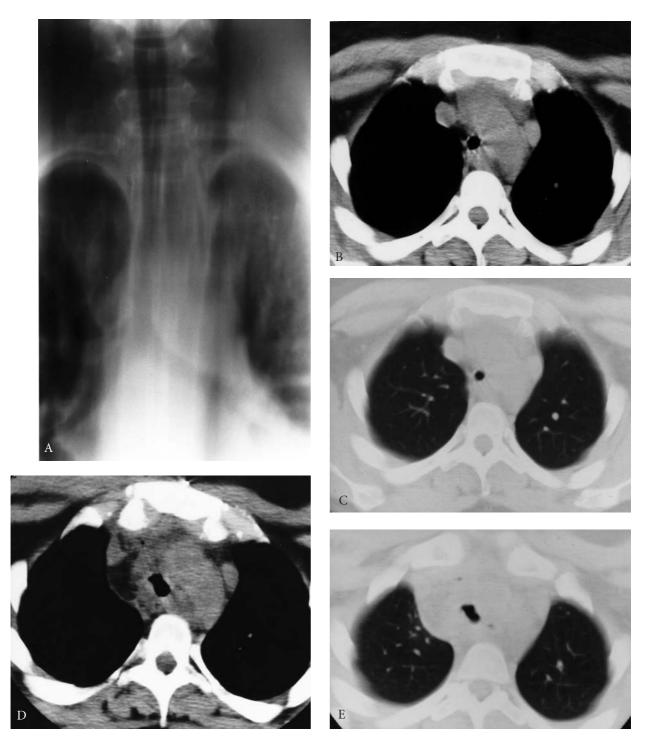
Congenital tracheal stenosis. A, Coronal tomogram demonstrates diffuse stenosis of the intrathoracic trachea. B, Computed tomography image through the midtrachea reveals a complete cartilaginous tracheal ring and significant stenosis of the trachea (C). D,E, Following a slide tracheoplasty procedure, the tracheal lumen is significantly greater.
